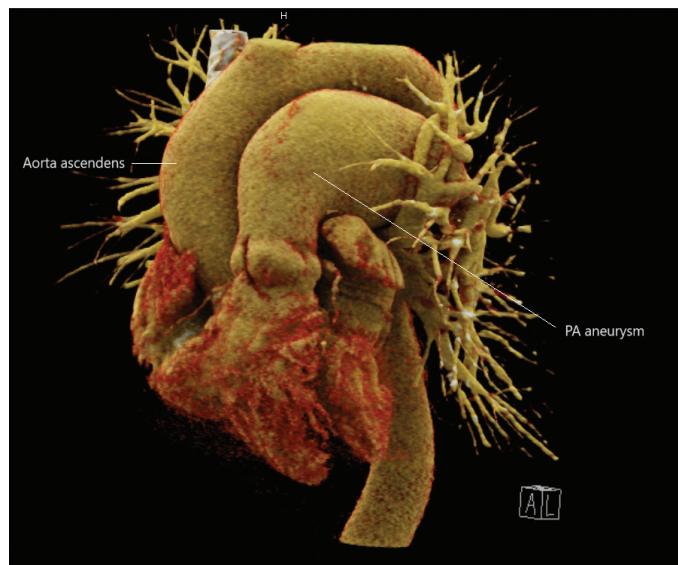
and Video 2. CT pulmonary angiogram 3D reconstruction reveals an aneurysmal main pulmonary artery. PV indicates pulmonary artery. CT, computed tomography; PV, pulmonary valve.
